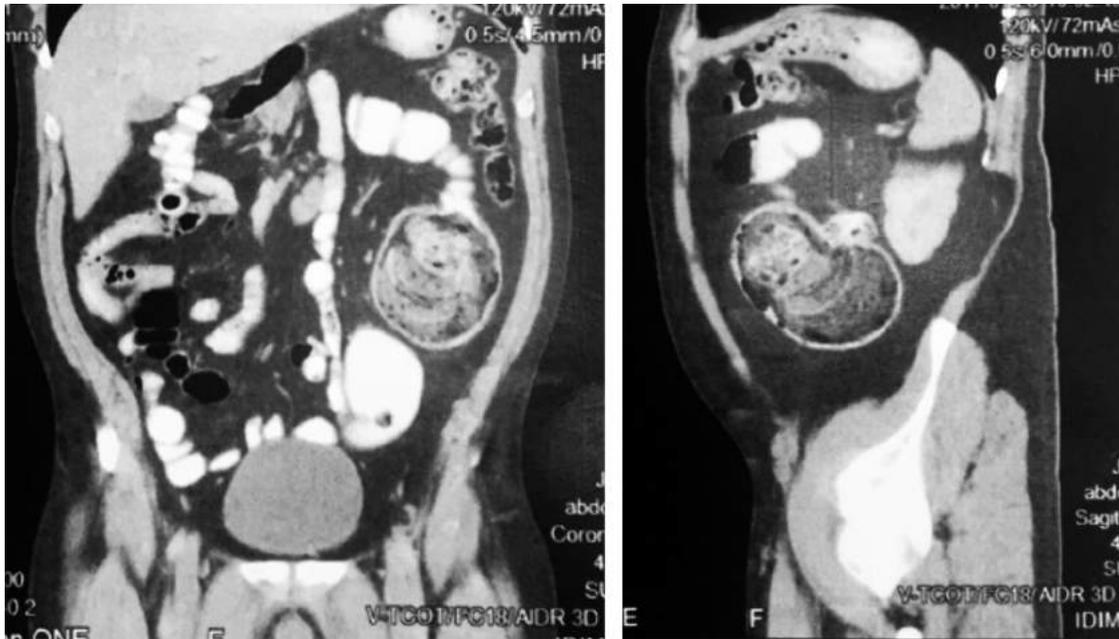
CT with double contrast, coronal and sagittal section (lesion indicated by the arrow). Source: Patient's medical record.
